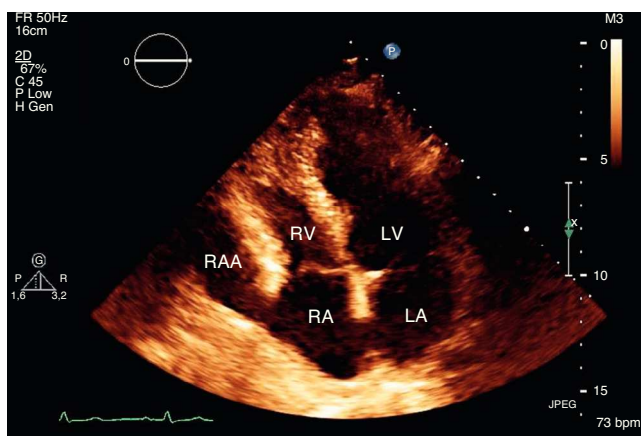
Transthoracic echocardiogram, apical 4-chamber view. LA: left atrium; LV: left ventricle; RA: right atrium; RAA: right atrial aneurysm; RV: right ventricle.
